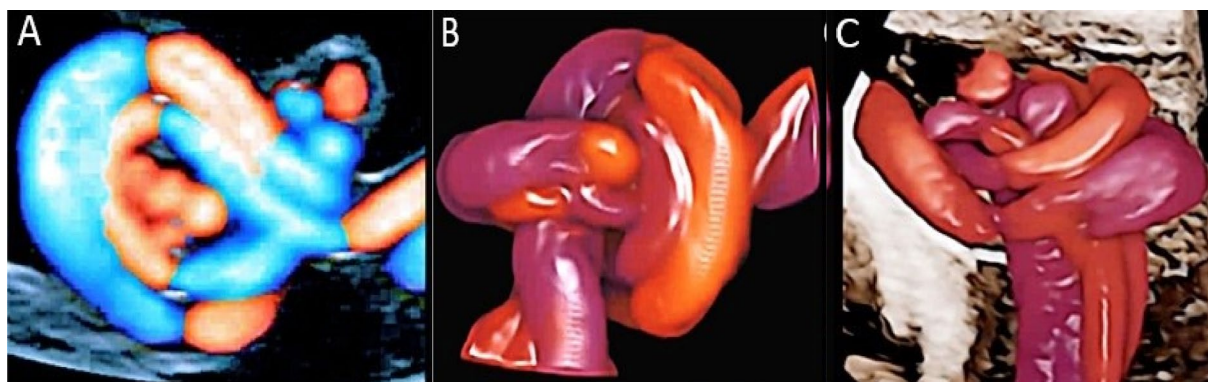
(A) 3D ultrasound was performed with 4D angio spatio-temporal image correlation and “glass body” rendering mode in a case of true cord knot and thrombosis of the umbilical artery with gross pathology confirmation (B).
